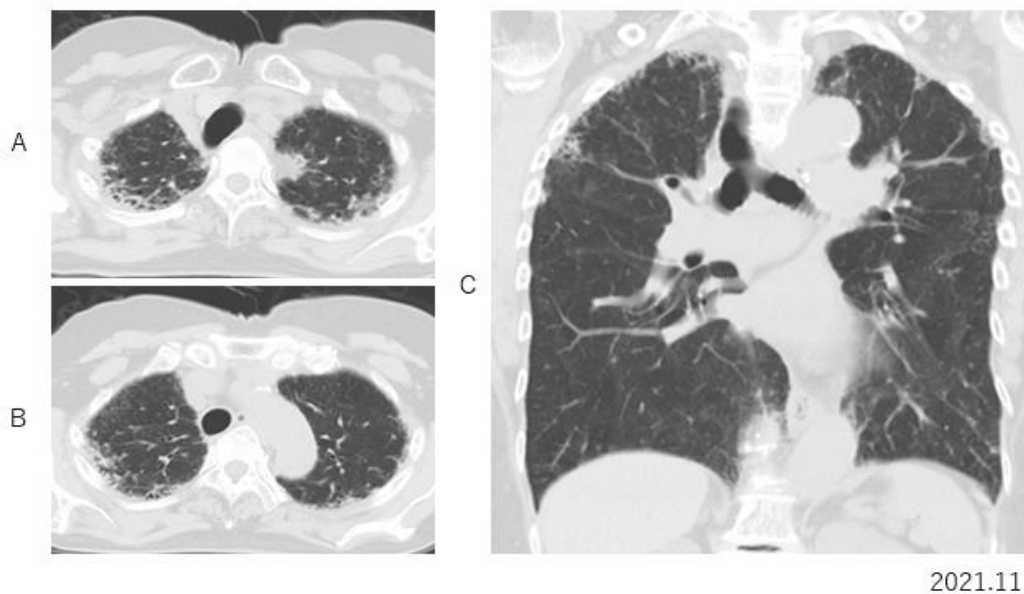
In bilateral apex, mild reticular fibrous pleural thickening is depicted on axial (A, B) and coronal CT.
